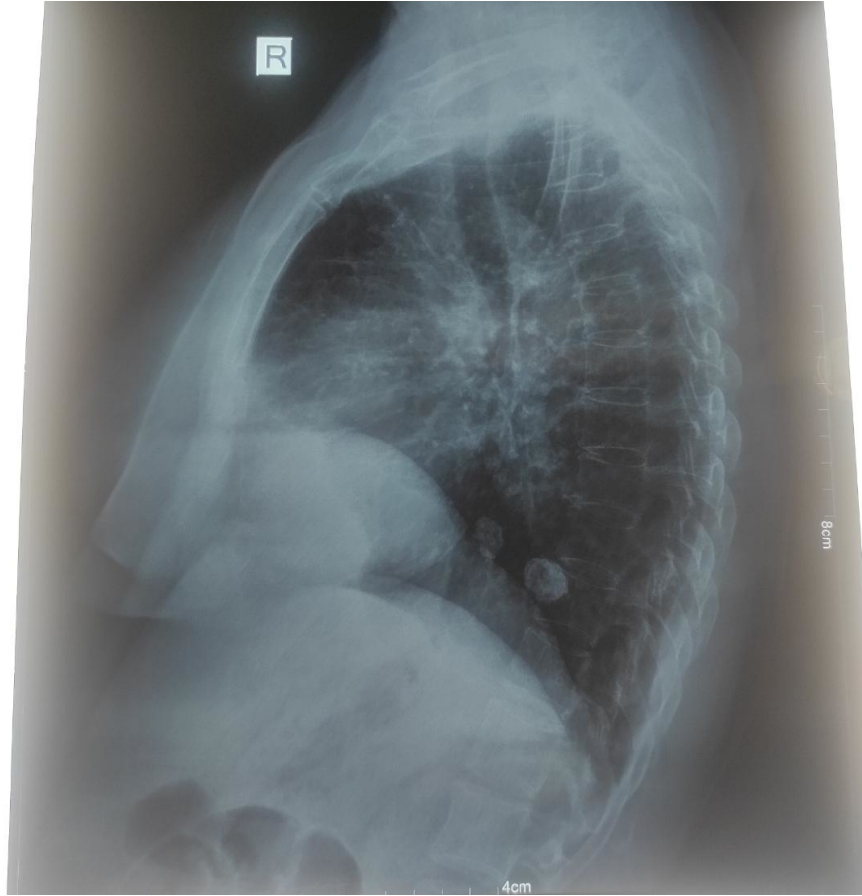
Repeat chest Xray lateral view on a follow up visit
